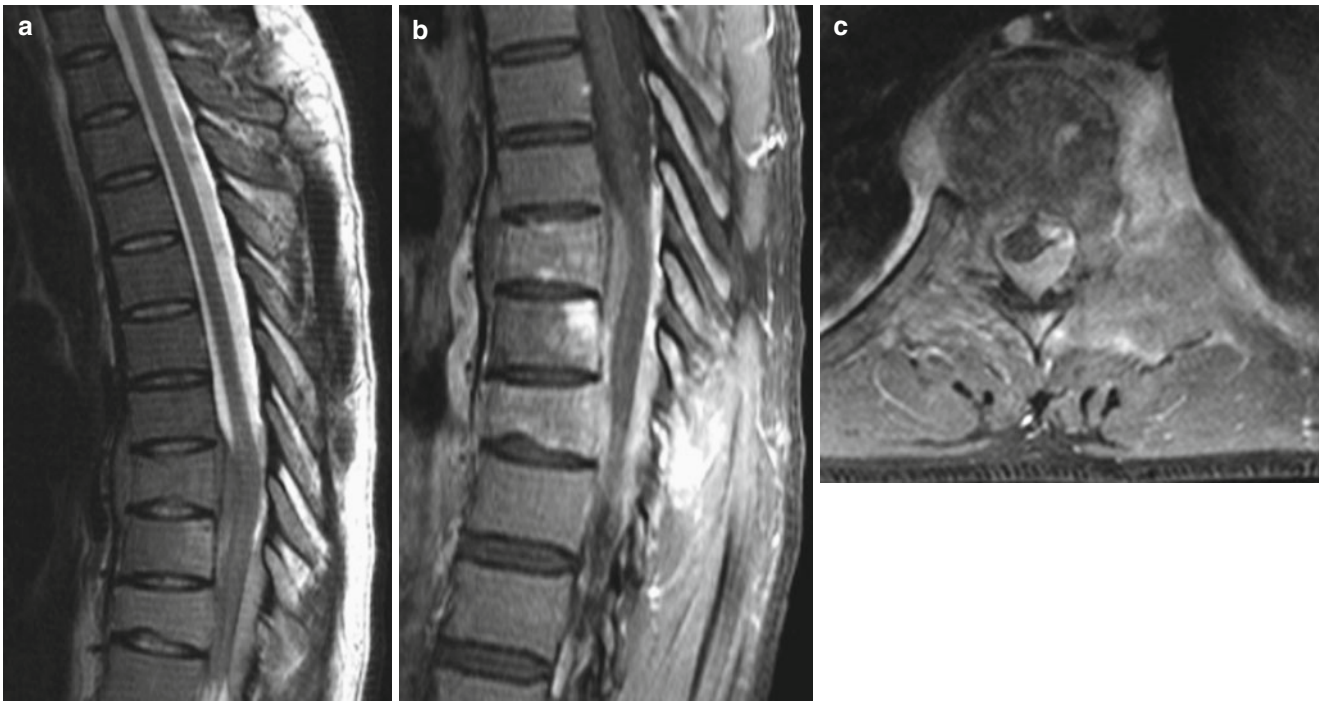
Epidural spinal lymphoma. (a) Sagittal T2-weighted image shows epidural mass compressing the thecal sac. (b, c) Sagittal and axial Gd-enhanced T1-weighted scans reveal enhancing epidural and paraspinal masses, as well as involvement of three lower thoracic vertebrae
